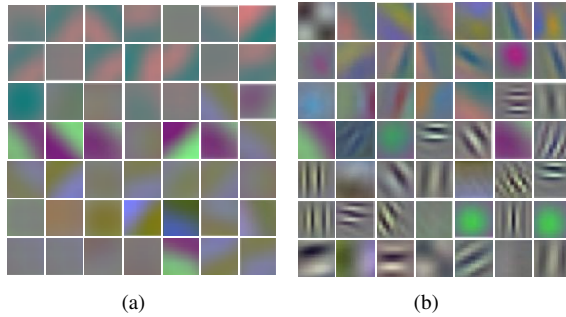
Visualization of the first-layer convolution filters of CNNs with random initialization from original CT images and image enhancement. Many higher orders of contrast or boundary-preserving patterns are evidently learned through image enhancement. (a) Learned from original images. (b) Learned from the images enhancement.
